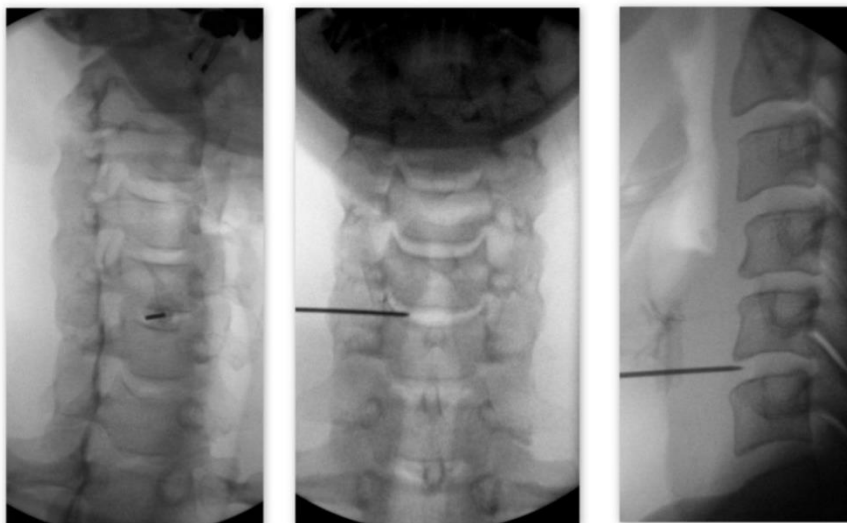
C-arm fluoroscopic images in oblique, anteroposterior and lateral planes of the needle onto the intervertebral disc level C4-C5. Images belong to Frank Blommers, Diagnostic radiographer, Albert Schweitzer Hospital, Slidrecht, the Netherlands and are used after reprint request.
